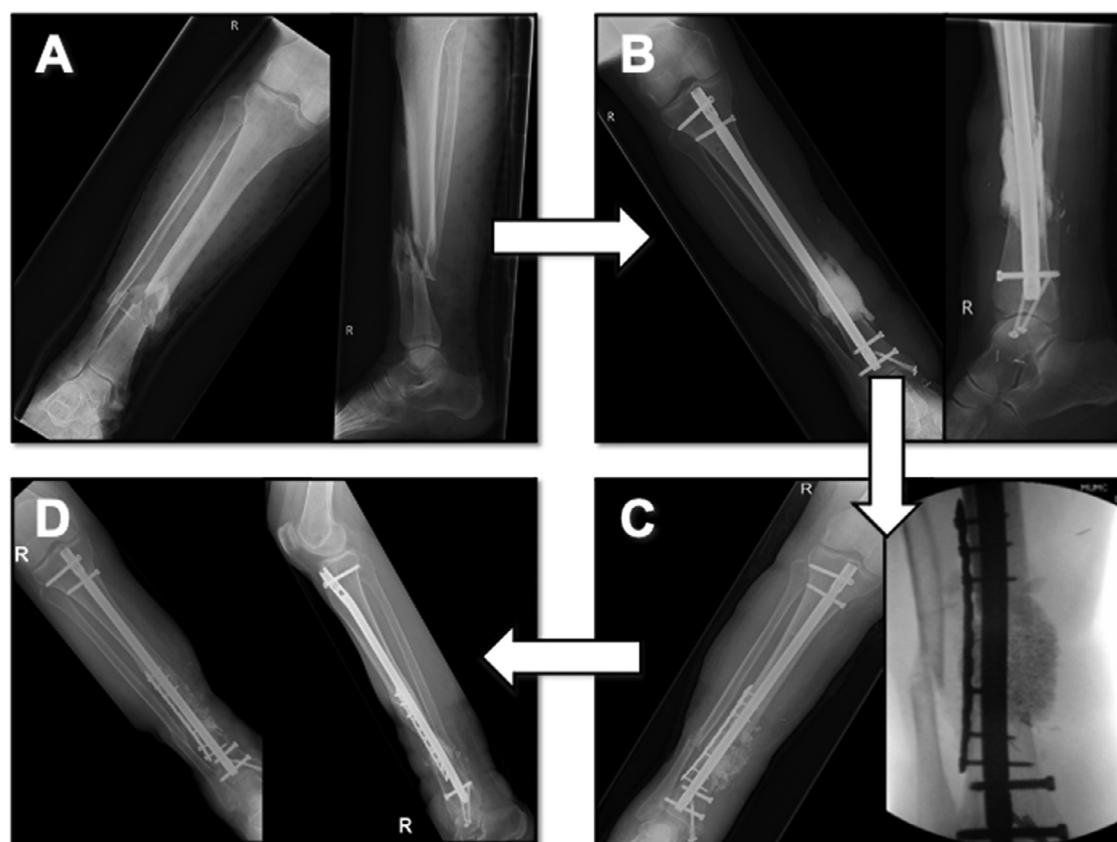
Example of the use of BAG for an open right tibia fracture addressed with an induced membrane and with a high risk of infection (A: pre-operative X-Rays, B: First stage X-Rays, C: Second stage X-Rays, D: X-Rays at 1 year last follow-up).
